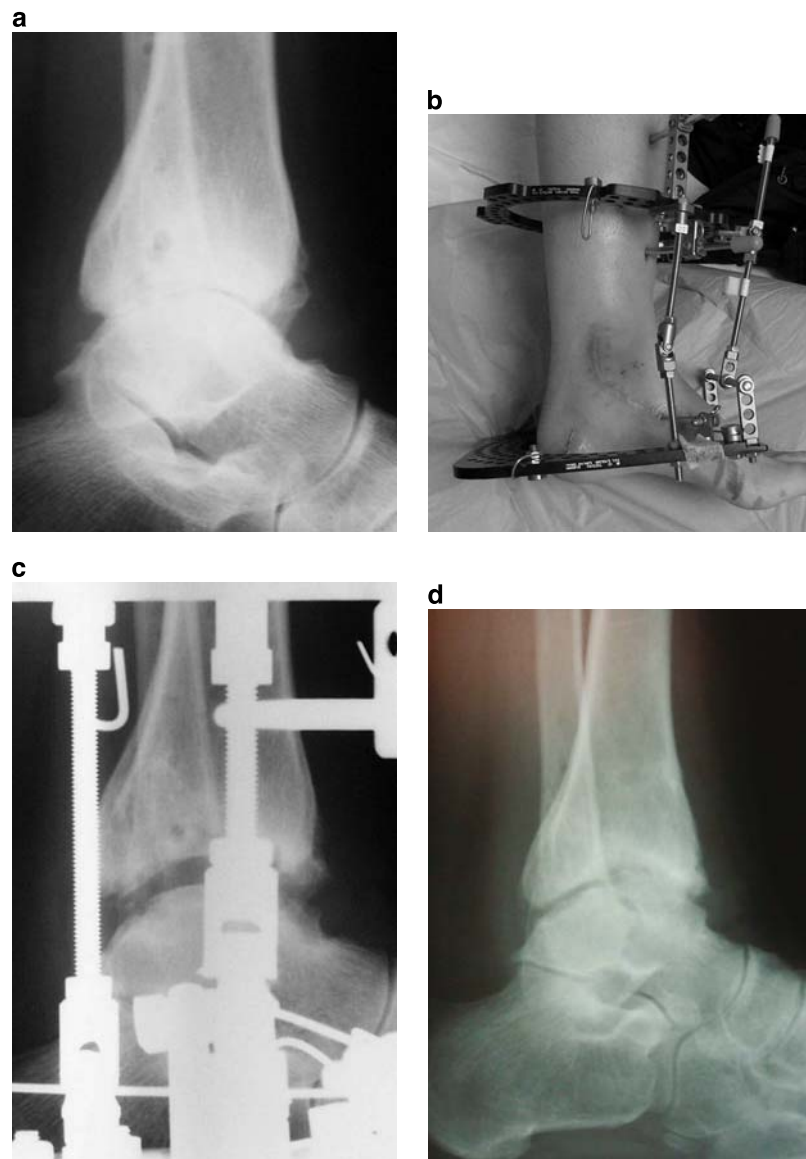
a Lateral radiograph of ankle showing arthritis with no deformity. b Side view of an ankle distraction frame with hinges at the axis of the ankle. c Lateral radiograph showing distraction of the ankle. d Lateral radiograph of the ankle 6 months after frame removal showing an increased joint space. Clinical symptoms were significantly improved
